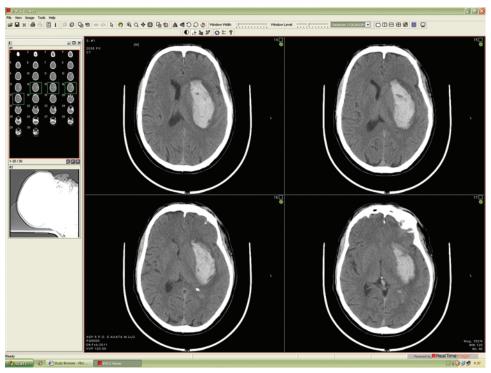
Telemedicine screenshot showing multiple slices of brain CTs obtained in a 45-year-old patient with spontaneous nucleocapsular ICH. Telemedicine allowed rapid visualization of the CT and the collection of relevant clinical data. In general, nucleocapsular hematoma was not managed by central transfer, unless there was evidence of relevant mass effect with possible deterioration requiring neurointensive care or surgical control of ICP. Cautious conservative management led to a good outcome in this case.
